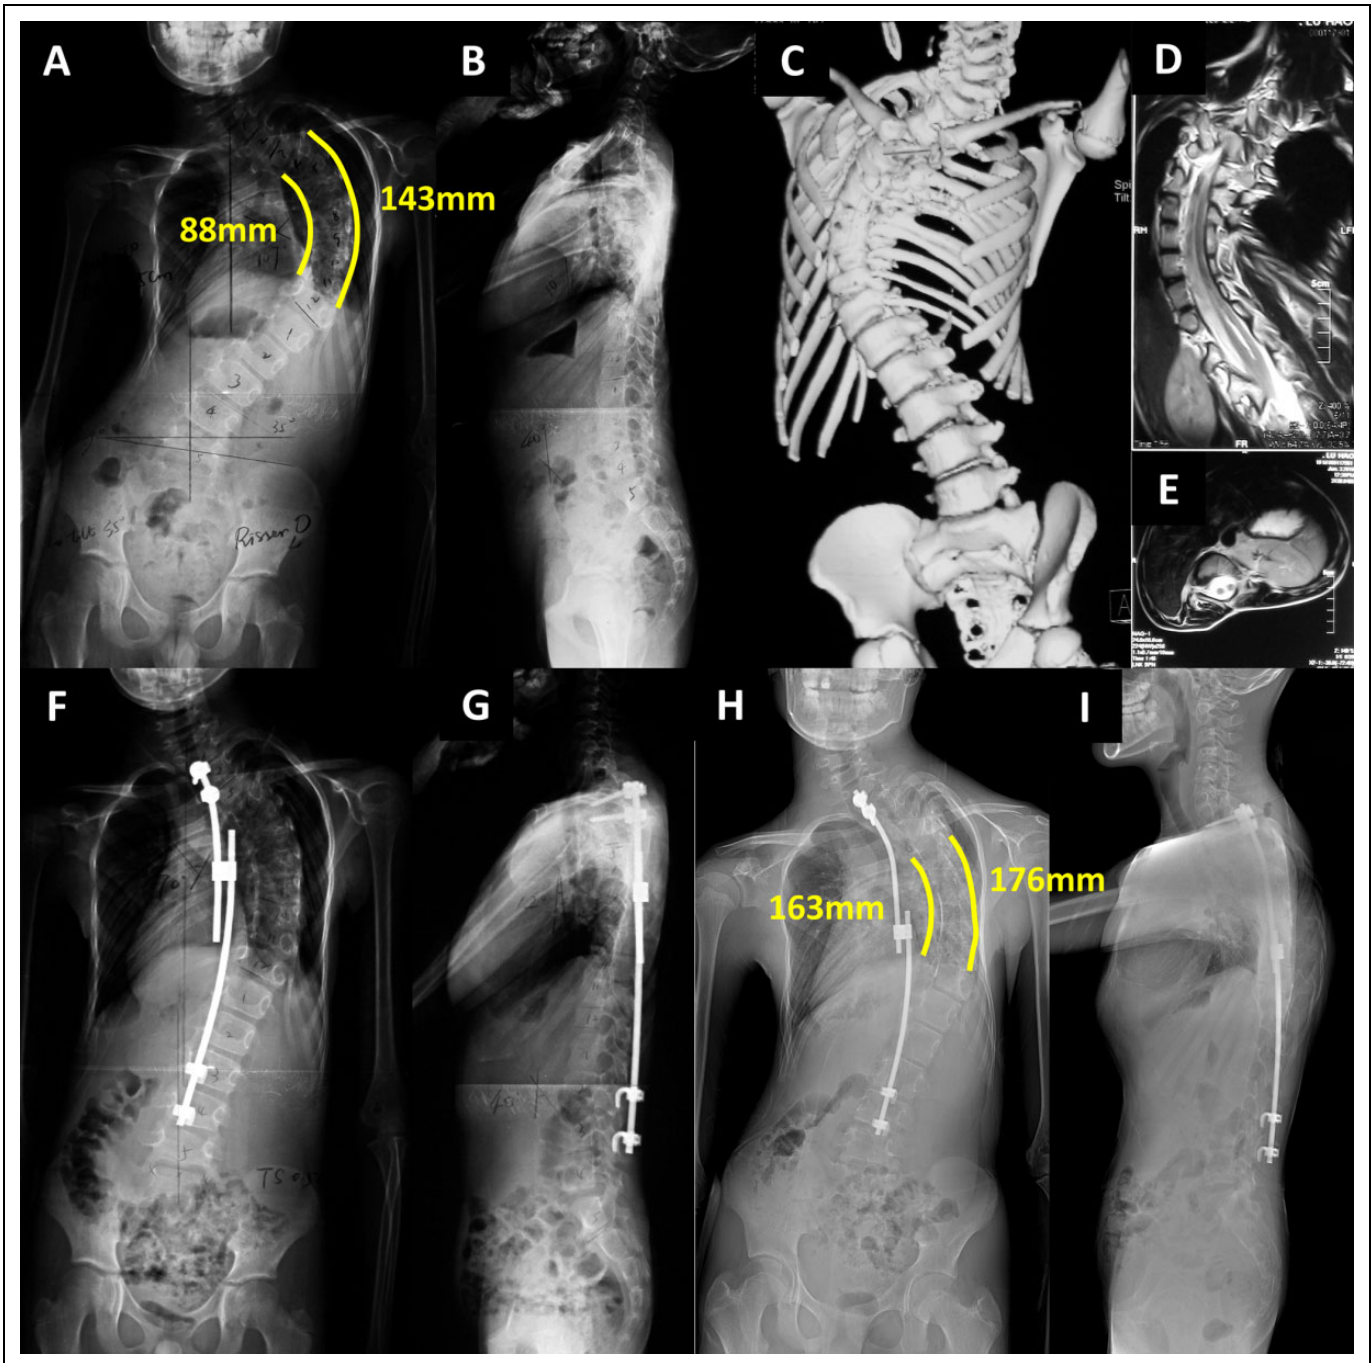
A & B) All-spine radiographs before index surgery; C) 3-D CT showed extensive vertebral malformation and segmentation failure; D & E) T2-weighted coronal and axial MRI identified type 2 split cord malformation at the thoracolumbar area. F & G) After index surgery. H & I) After seventh distraction with in-situ fusion.
